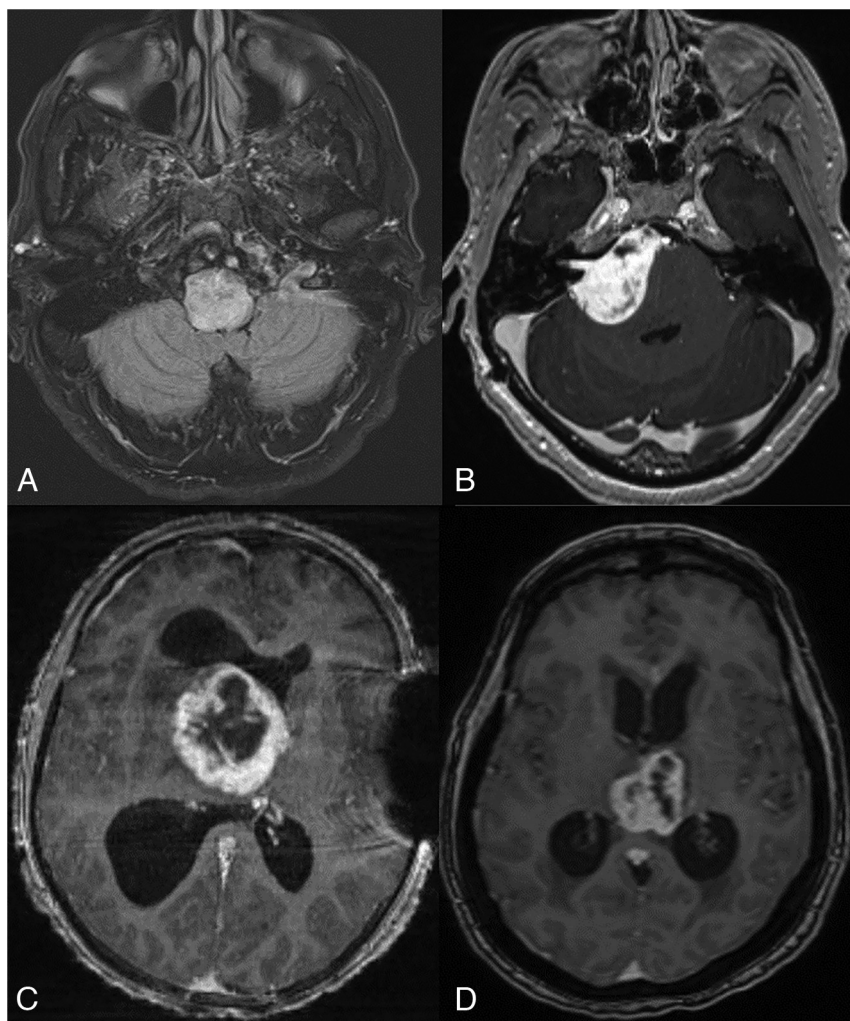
Postcontrast FLAIR axial MR image in a 44-year-old man (A) with dyspnea and vocal cord paralysis shows an expansile hyperintense lesion in the pontomedullary region with patchy ill-defined enhancement (not shown). Postcontrast T1-weighted axial MR images (not shown). B, A 32-year-old woman presenting with hearing loss demonstrates a large, right pontine tumor extending into the right cerebellopontine angle, internal auditory canal, and prepontine cistern. Postcontrast T1-weighted axial MR images (C and D) demonstrate a midline, diencephalic/thalamic region tumor with rim enhancement in a 19-year-old man (C) and a 71-year-old woman (D).
